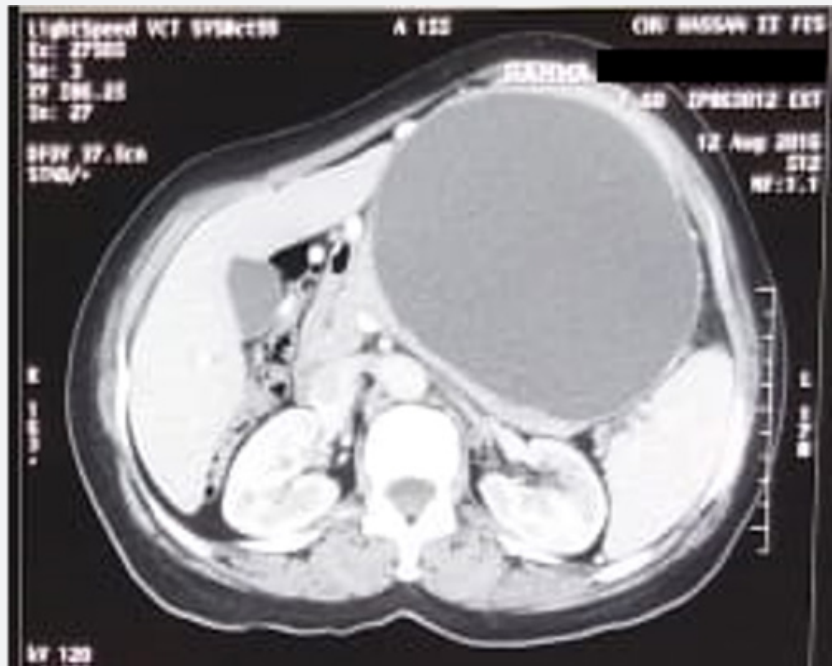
CT abdomen (axial view). Showing a pancreatic pseudocyst.
